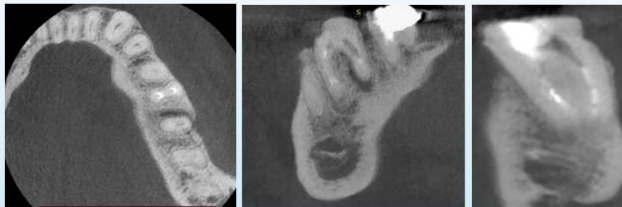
CBCT images after the first treatment session
